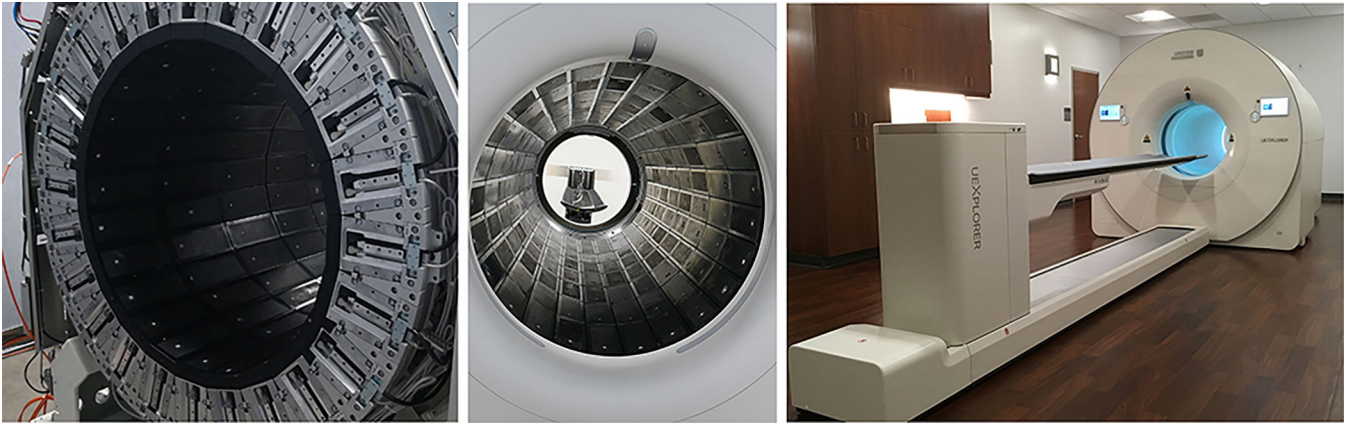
Photographs of the uEXPLORER total-body PET/CT scanner during construction and after installation at UC Davis.
